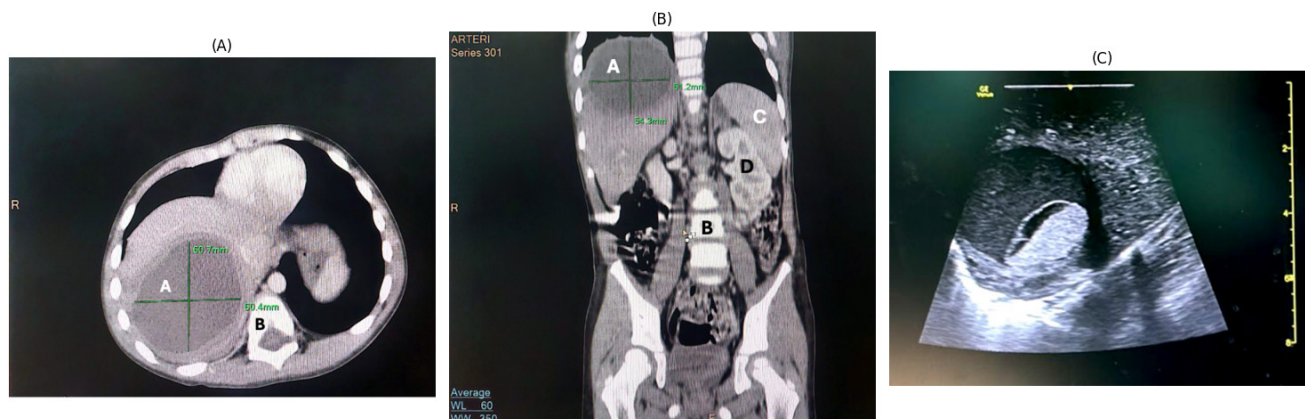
Radiological evaluation of liver abscess. (A) Axial contrast-enhanced CT showing a hypodense lesion (~6 cm) in segment VII. (B) Coronal CT demonstrating the extent and anatomical relationships of the lesion. (C) Ultrasound showing a hypochoic lesion consistent with liver abscess.
